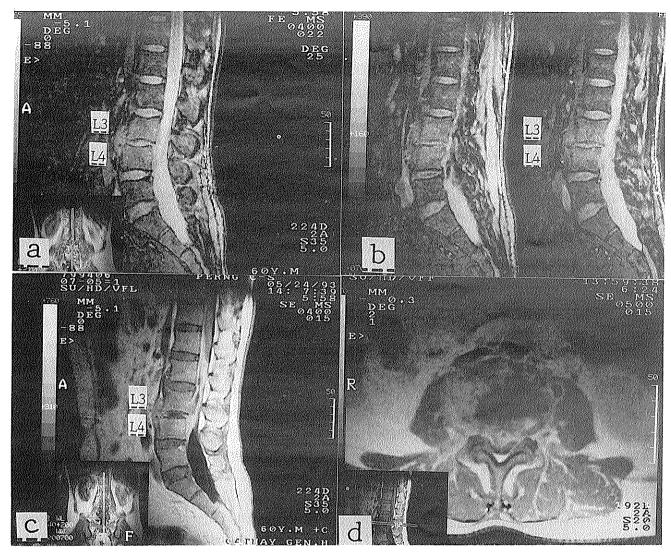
MRI of L-S spine one month after admission. (a, b): Sagittal T2*WI showing absence of intranuclear cleft and linear appearance of the L3-L4 IVD and increased signal intensity of L3 and L4 bodies. (c, d): increased enhancement of the epidural lesion and psoas muscles on sagittal and axial Gd-T1WI as compared with fig. 4-b, c.
